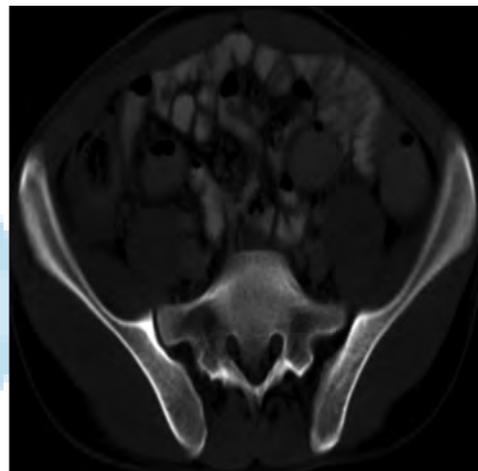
CT photograph showing normal abdomen
